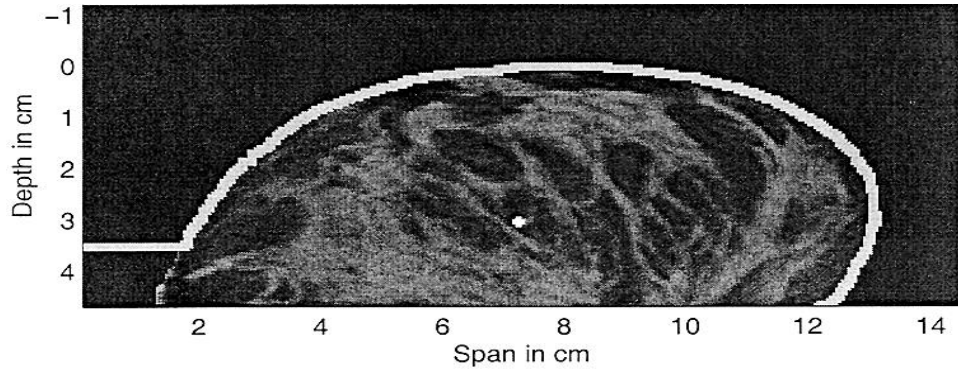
Two-dimensional dielectric-properties breast model derived from an MRI scan. A 2-mm diameter malignant tumor has been inserted at a depth of 3.1 cm.
